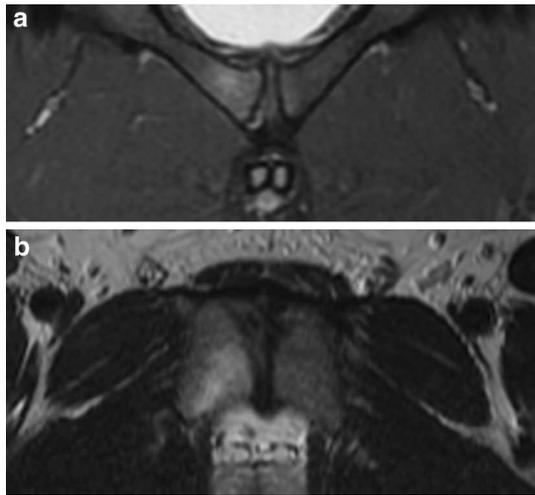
a, b Osteitis pubis in an amateur football player (MRI, T2 +contrast agent, coronal and axial plane): unilateral bone bruise on the right os pubis
